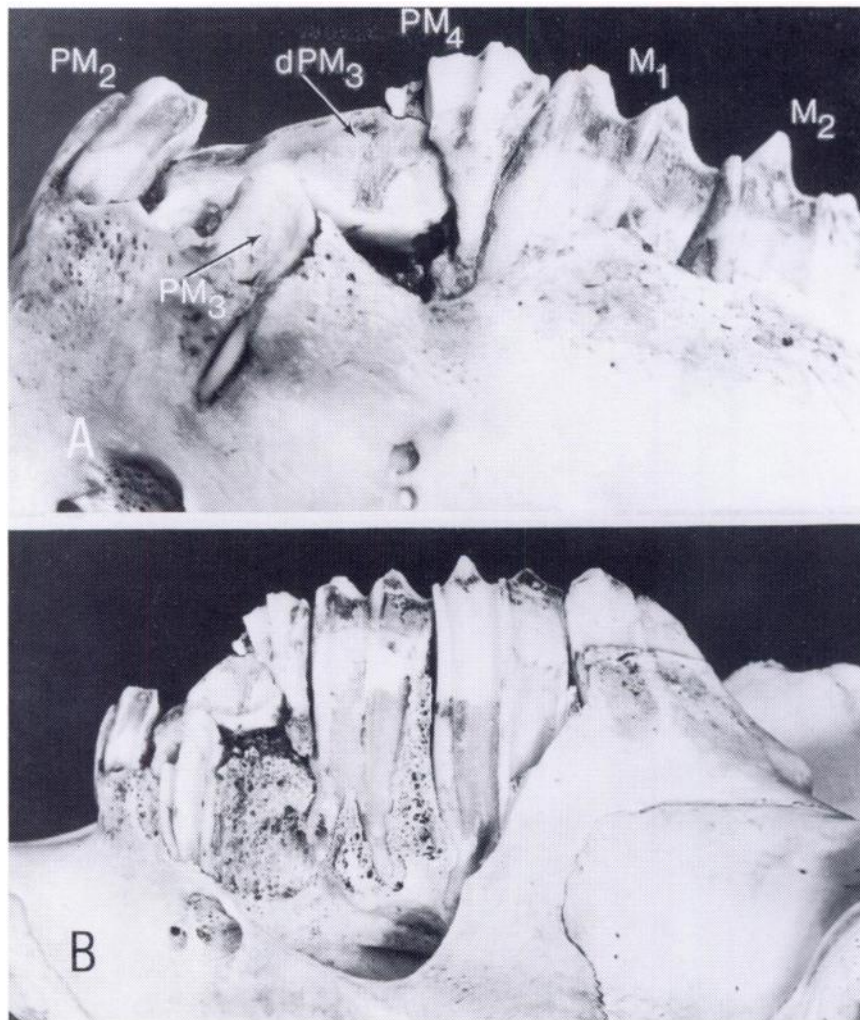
Partial buccal view showing the horizontal eruption of the dPM³, impactation of the PM⁴, an apparent pressure resorption of PM¹ and periapical infection of PM³ (A). Removal of the maxillary shield revealed a tract of osteolytic bone penetrating the maxillary sinus (B).
